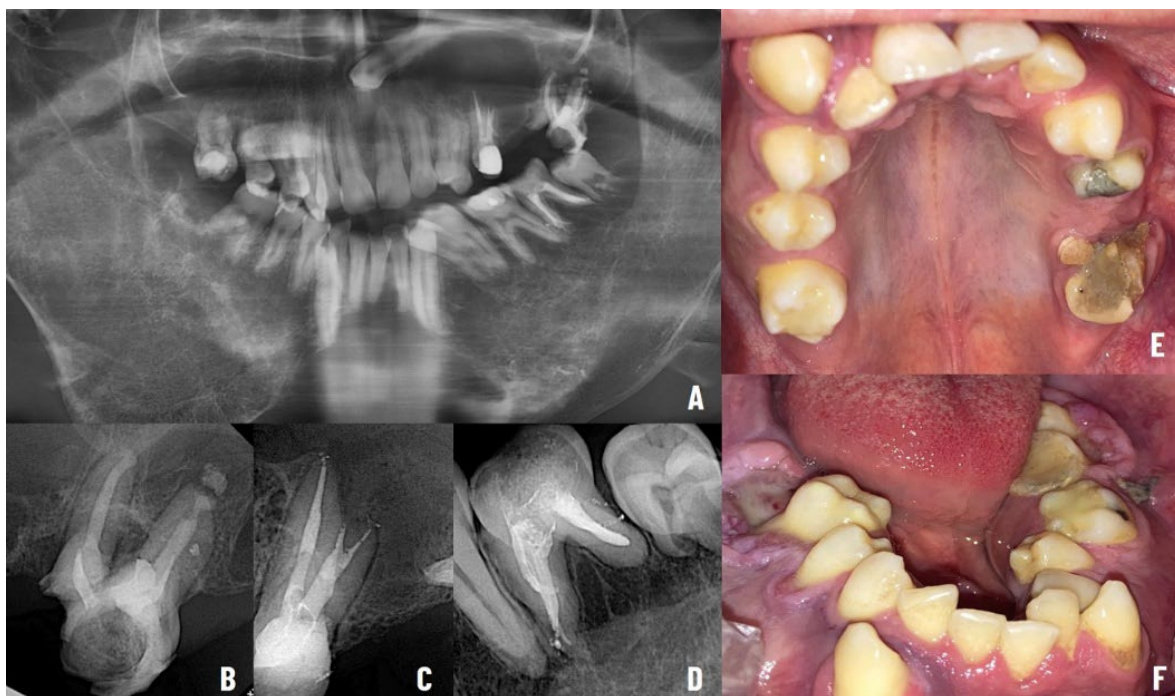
9-month follow-up radiographs: A) Panoramic view; B) Tooth #27 periapical view; C) Tooth #25 periapical view; D) Tooth #37 periapical view; E) Clinical view of maxillary arch; F) Clinical view of mandibular arch
